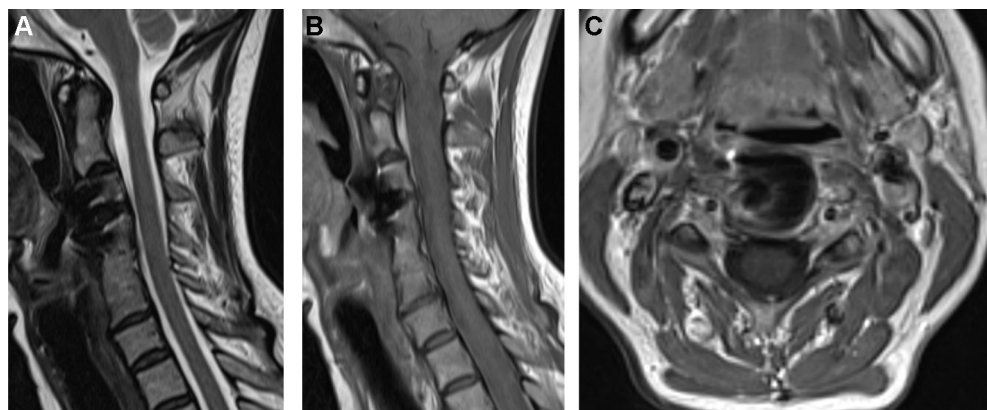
A–C. In MRI examination 4 weeks after discontinuation of antibiotic therapy no more signs of discitis or prevertebral abscess in T2 sequences (3A) or T1 sequences with gadolinium (3B and 3C) are detectable in.
